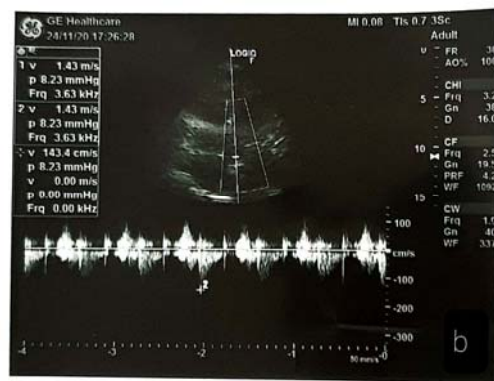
(b): Color flow Doppler was used to observe whether there was any right-left shunt at the foramen ovale of the interatrial septum.
